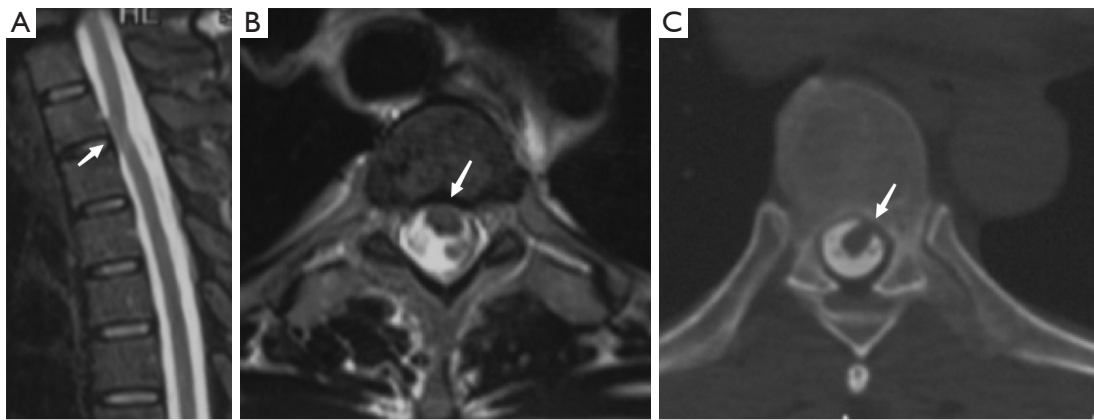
Preoperative imaging of idiopathic spinal cord herniation. (A) T2-weighted magnetic resonance imaging shows ventral herniation of the spinal cord at the T2–3 level with enlarged cerebrospinal fluid space on sagittal and (B) axial views in case 7. (C) Axial computed tomography myelography shows ventrolateral displacement of the spinal cord and widening of the dorsal space in case 6. White arrows indicate the position of the dural defect.
